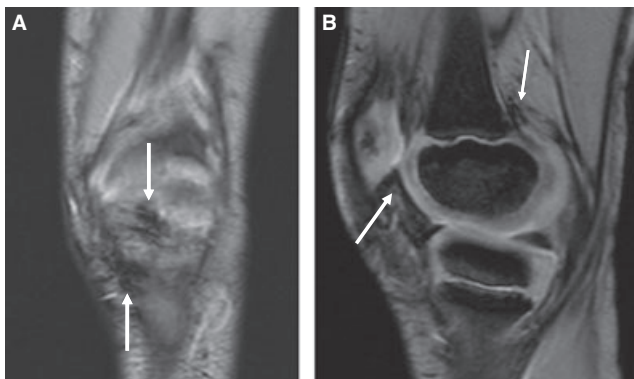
Ten-year-old boy with severe hemophilia A and no history of previous bleeds into the left ankle. MRI images of the patient's left ankle show moderate synovial proliferation (score 2, A-scale; score 5, P-scale), hemosiderin deposition (score 1, A-scale; score 5, P-scale) (long arrows; A, B) and joint effusion (short arrow; C). No obvious osteochondral abnormalities were identified.
